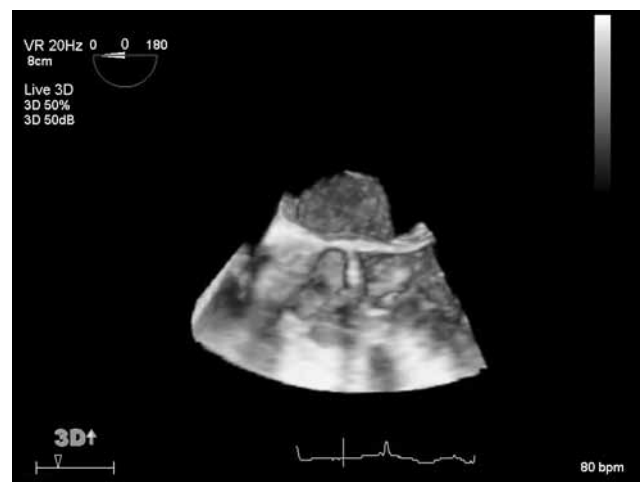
RT-3D transesophageal echocardiography image of myxoma.
